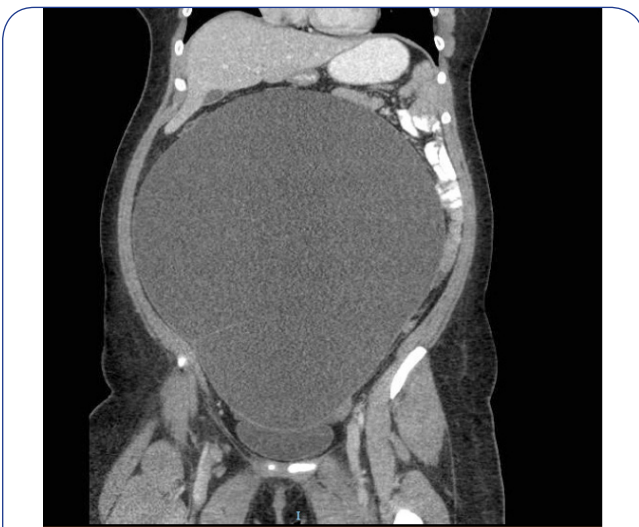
CT scan Abdomen/pelvis showing large abdominopelvic mass with mucinous features
